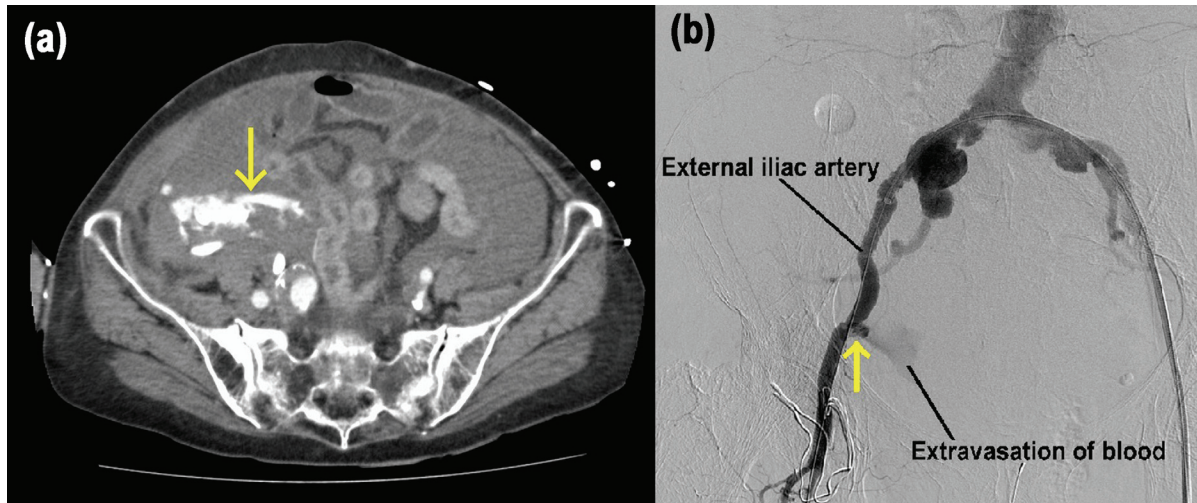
(a) Contrast-enhanced computed tomography image shows free fluid in the retroperitoneal and intraabdominal cavities, suggestive of retroperitoneal haemorrhage which perforated into the abdominal cavity with extravasation of the contrast material (arrow), indicating an ongoing haemorrhage. (b) Digital subtraction angiography shows bleeding at the damaged site of the external iliac artery (arrow)
